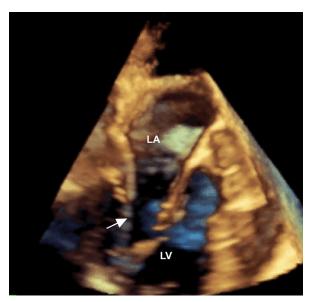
Three-dimensional transesophageal echocardiogram shows a pacemaker wire (arrow) protruding into the left ventricle (LV).
